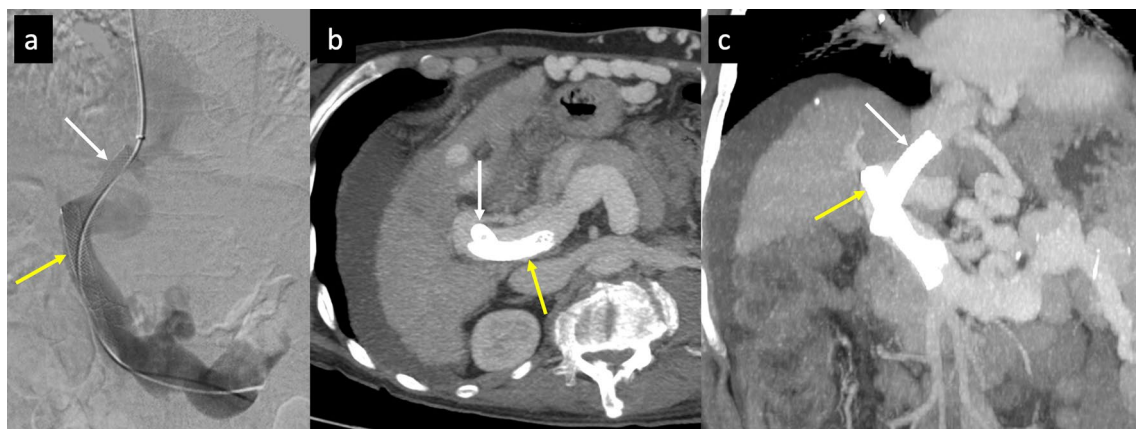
Stent migration. Angiographic (a) and CT maximum intensity projection (MIP) reconstruction (b, c) images in a patient with multiple stents. The first stent migrated inferiorly into the main portal
